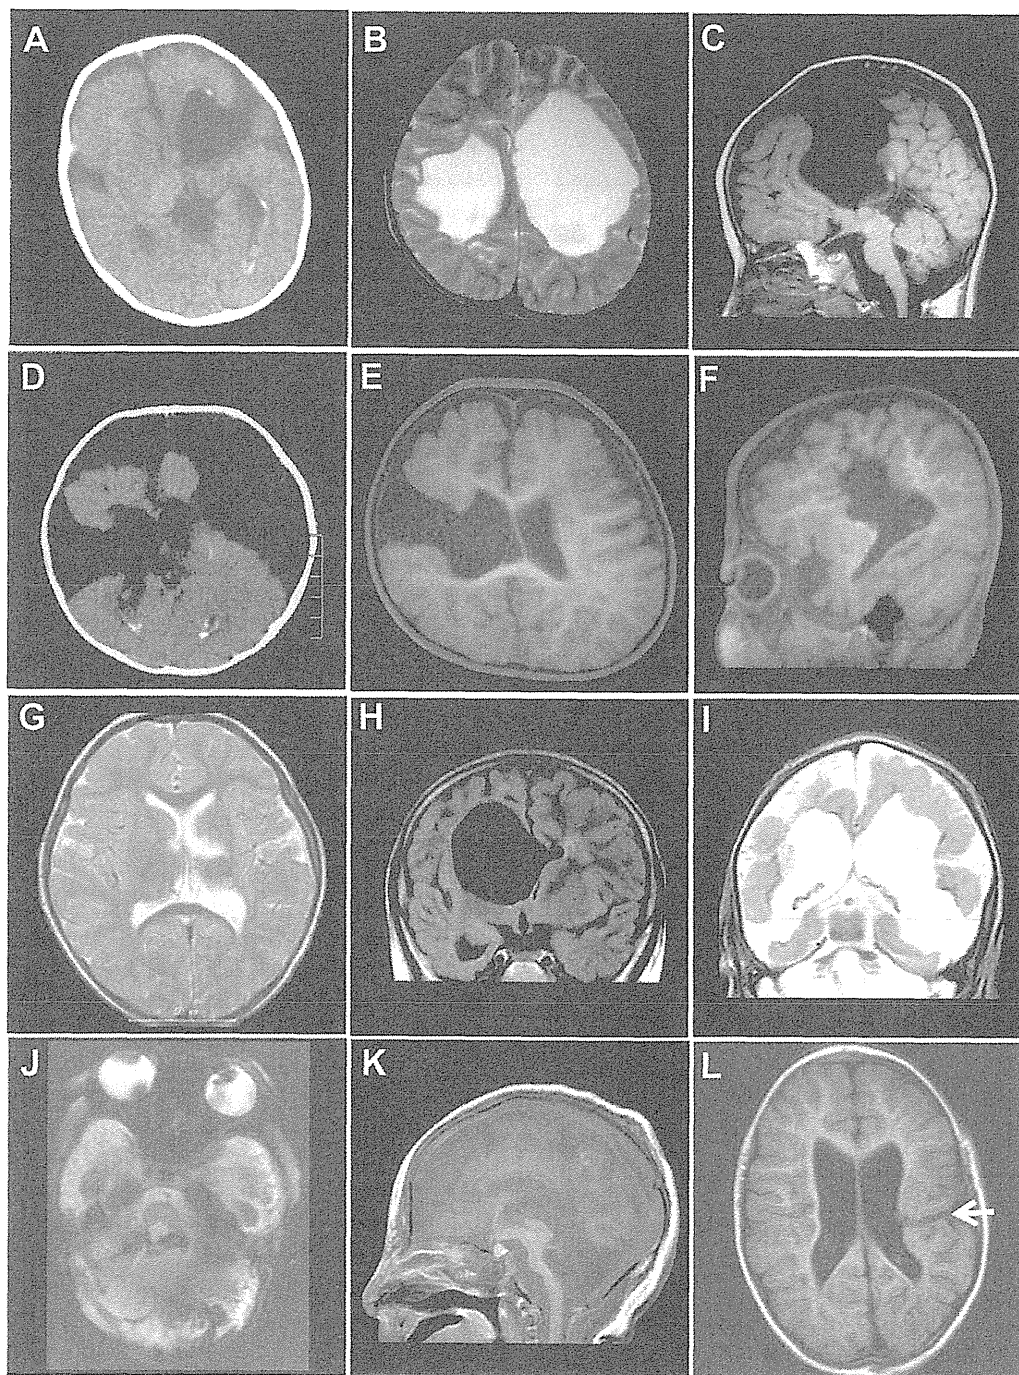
Computed tomography (CT) scan (A, D) and magnetic resonance imaging (MRI; B, C, E–L) of patients with *COL4A1* mutations. (A–C) Images of patient 1. (A) The CT scan shows calcification along with the dilated lateral ventricular wall. (B) T2-weighted and (C) T1-weighted images (WIs) at 5 years of age showing bilateral porencephaly. (D) The CT image of patient 2 with schizencephaly shows calcification of the lateral ventricular wall and brain parenchyma. (E, F) T1-WIs of patient 3 show unilateral schizencephaly at 15 months of age. (G) T2-WI of patient 4 at 3 years of age shows parenchymal defect of the left thalamus and basal ganglia due to subependymal hemorrhage. (H) Fluid-attenuated inversion recovery image of patient 7 at 6 years of age showing unilateral porencephaly. (I) T2-WI, (J) T2*-weighted gradient-echo image (WGRE), and (K) T1-WI of patient 9. (I) The MRI at 2 months of age shows bilateral porencephaly with low-intensity lesions along with a deformed ventricular wall, which has hemosiderin deposition and calcification. (J) T2*-WGRE showing hemosiderin deposition in the atrophic cerebellum. The atrophic pontocerebellar structures are also shown in (K). (L) T1-WI of patient 15 showed schizencephaly in the left hemisphere at 2 years of age.
